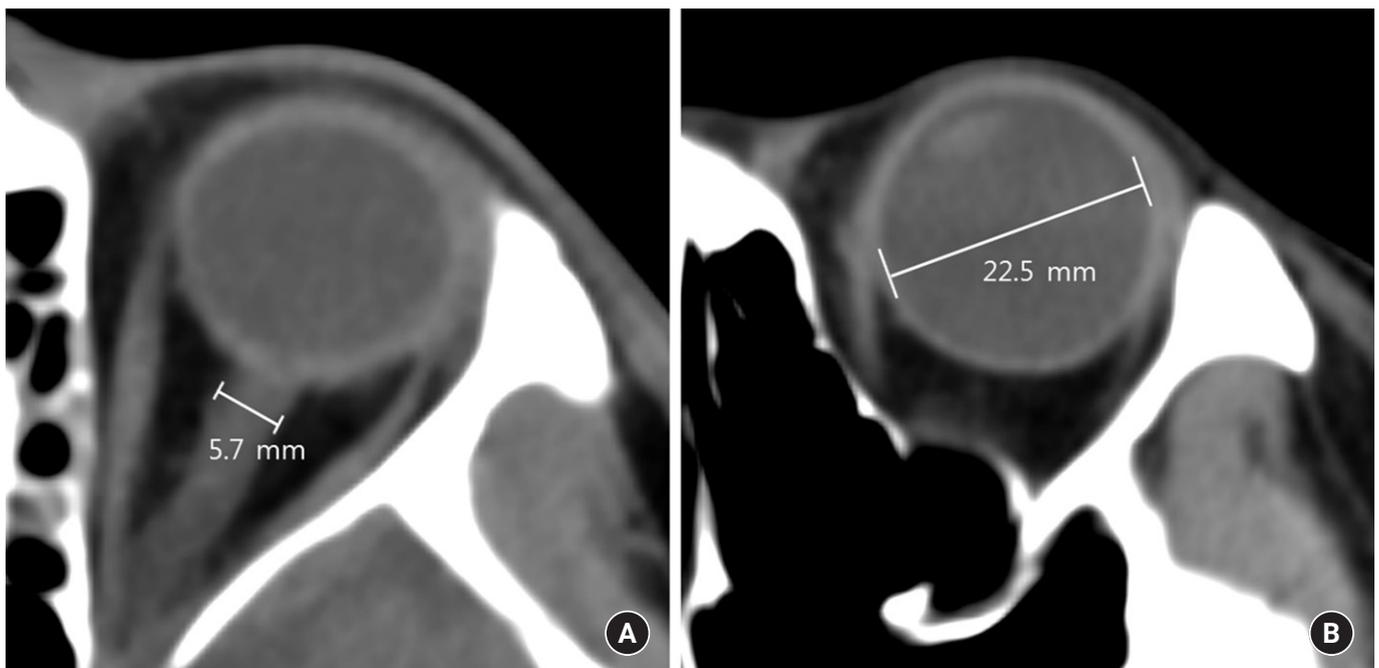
A: Measurement of optic nerve sheath diameter. B: Eyeball transverse diameter on brain computed tomography scan.
